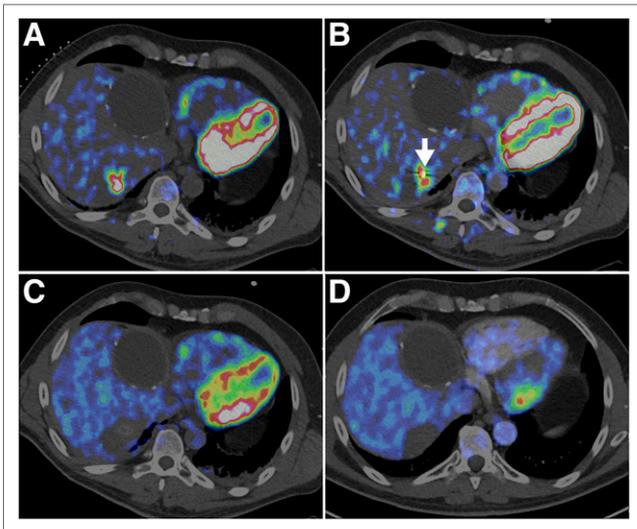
(A and B) Images before (A) and during (B) PET/CT-guided microwave ablation of metastasis using split-bolus approach. Arrow in intraprocedural image denotes microwave antenna. (C) Image immediately after ablation shows resolution of ^{18}F -FDG avidity, confirming treatment efficacy. (D) PET/CT 1 mo after ablation demonstrates no focal PET avidity.
